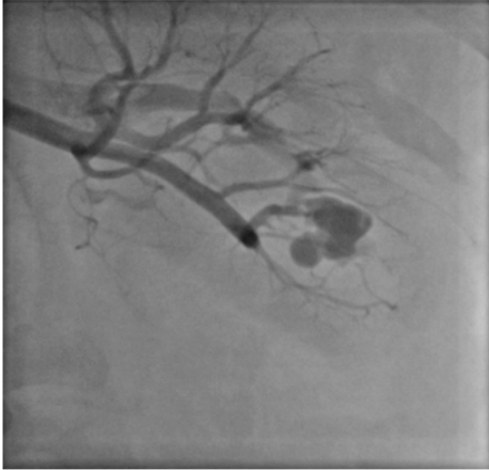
Multi Detector Computed Tomography (MDCT) scan. The arterial phase of angiography suggested early filling left renal vein with renal artery, indicating an arteriovenous fistula
